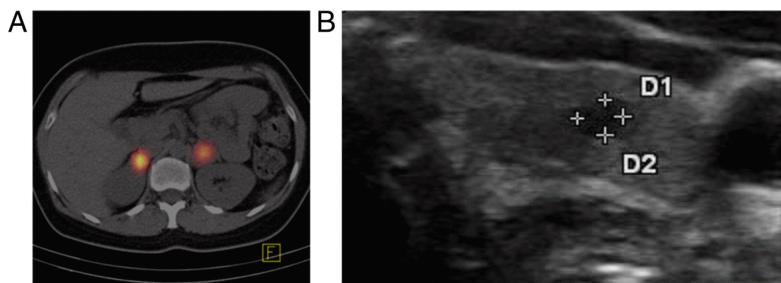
A, I-131 meta-iodobenzylguanidine positron emission tomography–computed tomography revealed bilateral adrenal masses with increased tracer accumulation suggesting bilateral pheochromocytoma. B, Thyroid ultrasound showed a 4-mm hypoechogetic nodule in the left thyroid lobe. D, diameter.
